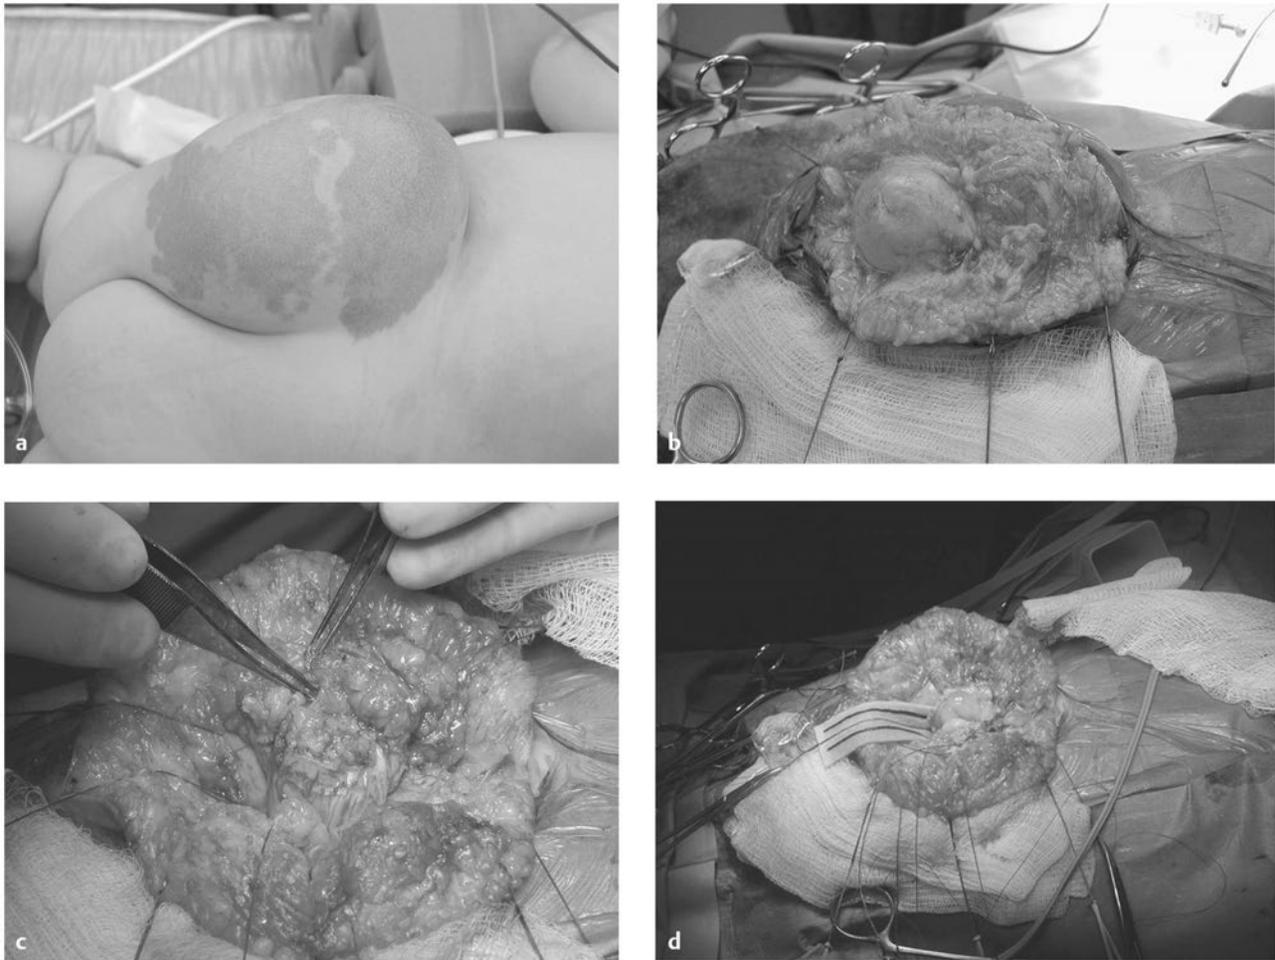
(a) Lipomyelocystocele. Spinal ultrasound demonstrated several cerebrospinal fluid (CSF)-containing spaces. The terminal myelocystocele was recognized with gentle ballottement of the mass and observation of expansion of the central canal rostral to the lesion. The other CSF space was presumed to be a meningocele. (b) Exposure of the meningocele. (c) Meningocele opened. Lateral aspect of the myelocystocele at the lipoma-root interface clearly seen. (d) Meningocele and myelocystocele opened. Central canal in view.
